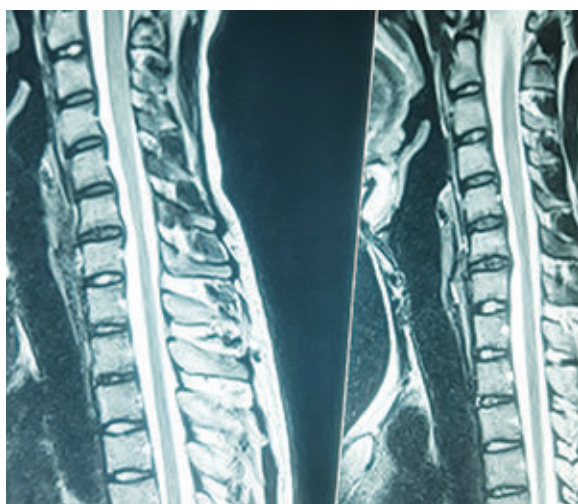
MRI of cervical spine in flexion view showing atrophy of the C5 and C6 segment of the spinal cord with some displacement of posterior dura.
